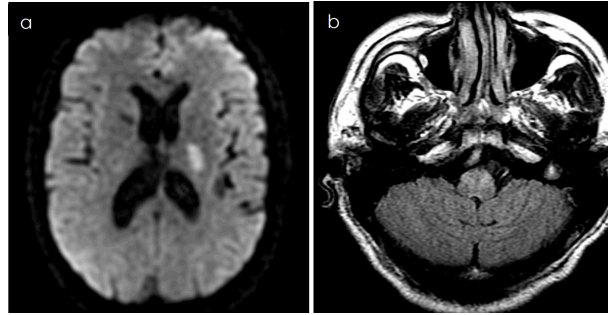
(a) Brain MRI showed increased diffusion-weighted imaging signal in the left internal capsule. (b) Increased signal in the left ventral lateral medulla on fluid-attenuated inversion recovery (FLAIR) MRI.
